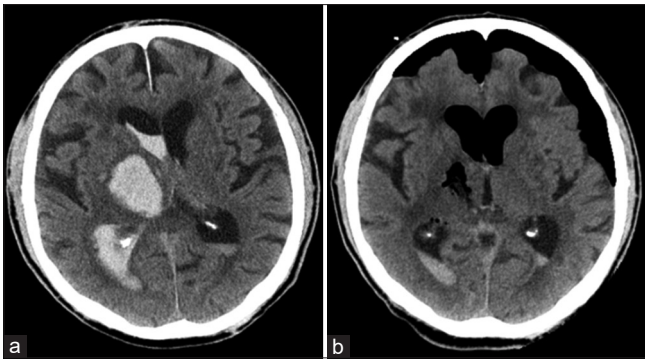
(a) Preoperative computed tomography reveals right thalamic hemorrhage and rupture into ventricles. (b) Postoperative computed tomography reveals complete evacuation of the thalamic hematoma
